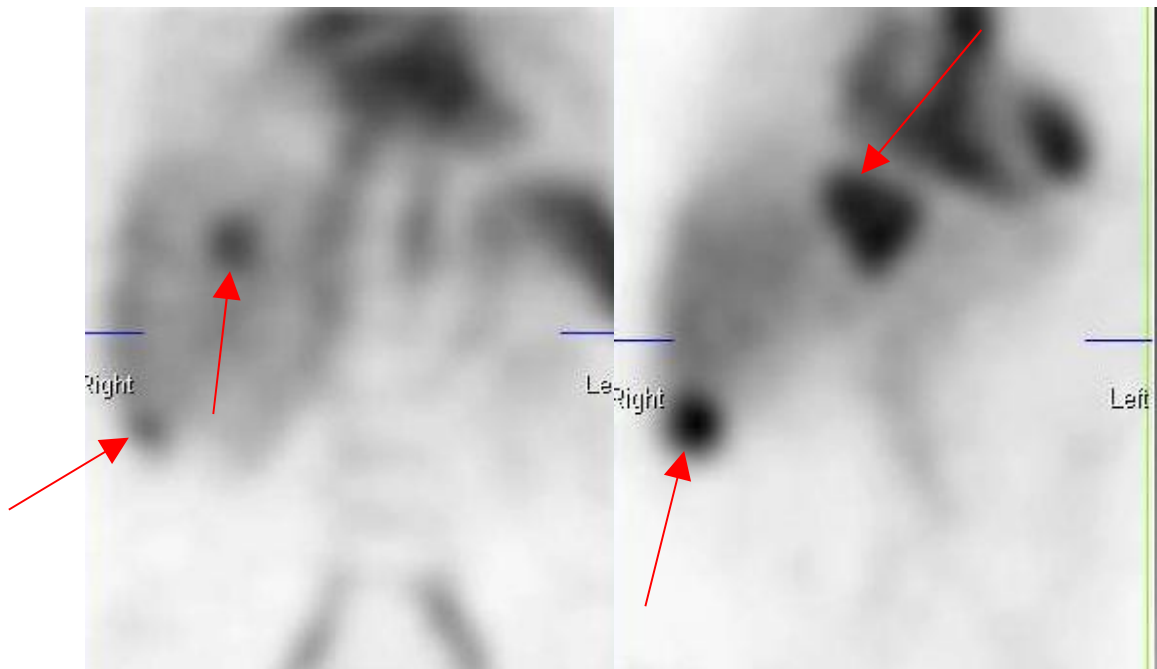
SPECT - Coronal slices of the RBC liver scan (arrows highlight the 4 lesions marked on the CT scan).
